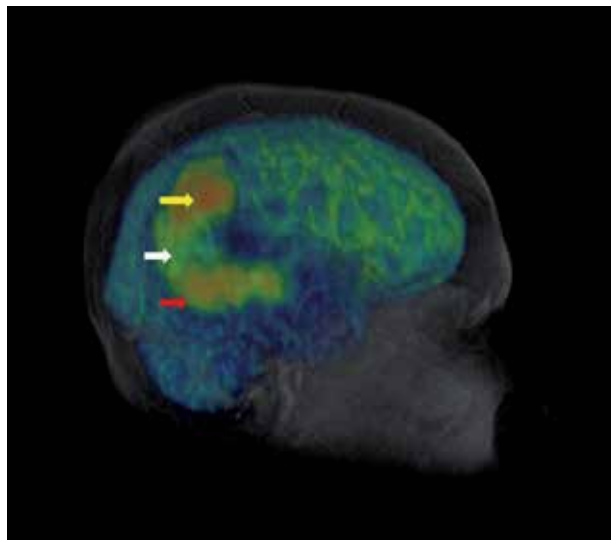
Female 22-year-old affected by GBM. Maximum intensity projection (MIP) fusion PET/3D spgr MRI image showing extensive lesion involving the right parietal-temporal lobe with heterogeneous increased [18F]FDG uptake, due to the lesion heterogeneity: high-grade component presenting elevated [18F]FDG activity with standardized uptake value ($SUV_{max}=17$) (yellow arrow), intermediate-grade component presenting $SUV_{max}=12$ (white arrow), low-grade component $SUV_{max}=4$ (red arrow).
